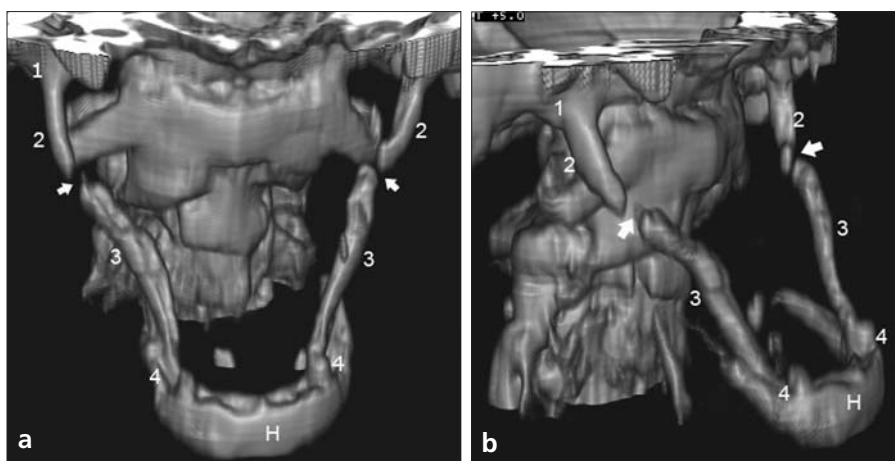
Anteroposterior (a) and oblique (b) 3D-CT images show ossification of the entire stylohyoid chain with a gap (arrows) between the second and third sections (1: tympanohyal segment; 2: stylohyal segment; 3: ceratohyal segment; 4: hypohyal segment; H: hyoid bone).
